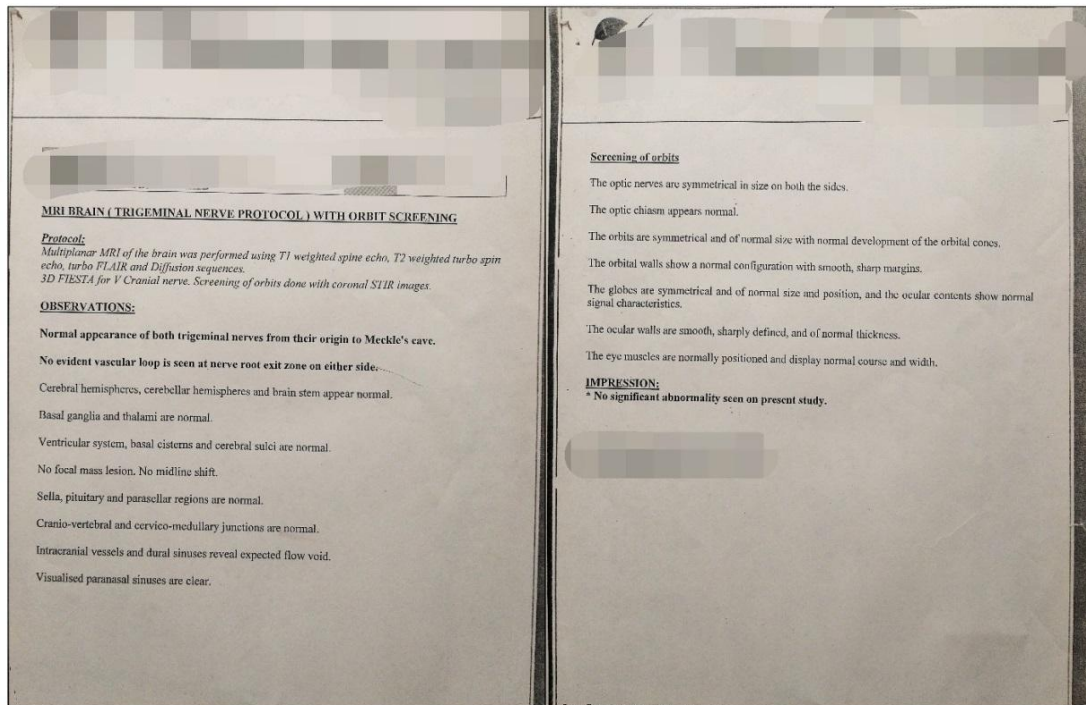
MRI report of brain
